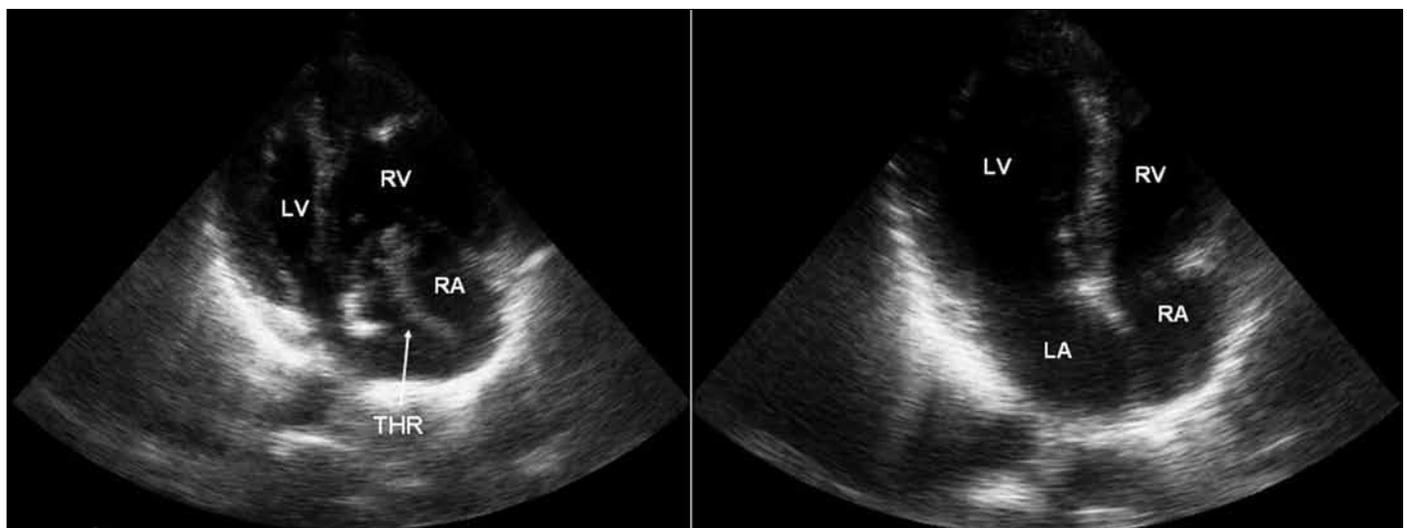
Left Panel:* Transthoracic echocardiography revealing significant increase in right ventricular size and a semi-mobile worm-like thrombus in the right atrium, which was entering the right ventricle at diastole. Note that the interventricular septum is shifted towards the left ventricle. *Right Panel:* After 100 mg continuous tissue plasminogen activator infusion over 2 hours, the thrombus dissolved completely. Note that right ventricular size and interventricular septum position are normal
